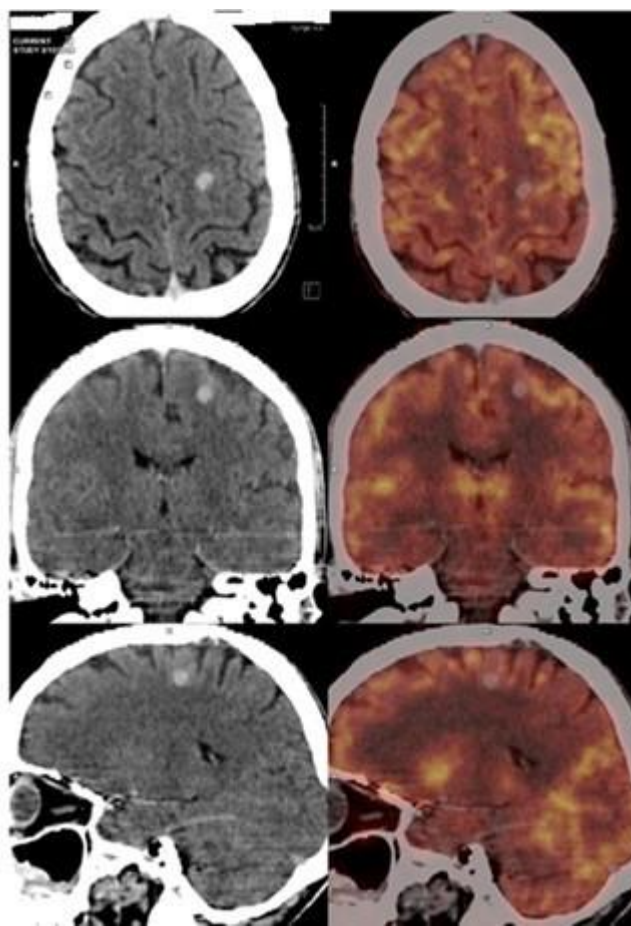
Multi-planar brain CT and fused PET–CT — enhancing left frontal subcortical nodule (0.9×0.8 cm) suspicious for cerebral metastasis; no other intracranial abnormality.
